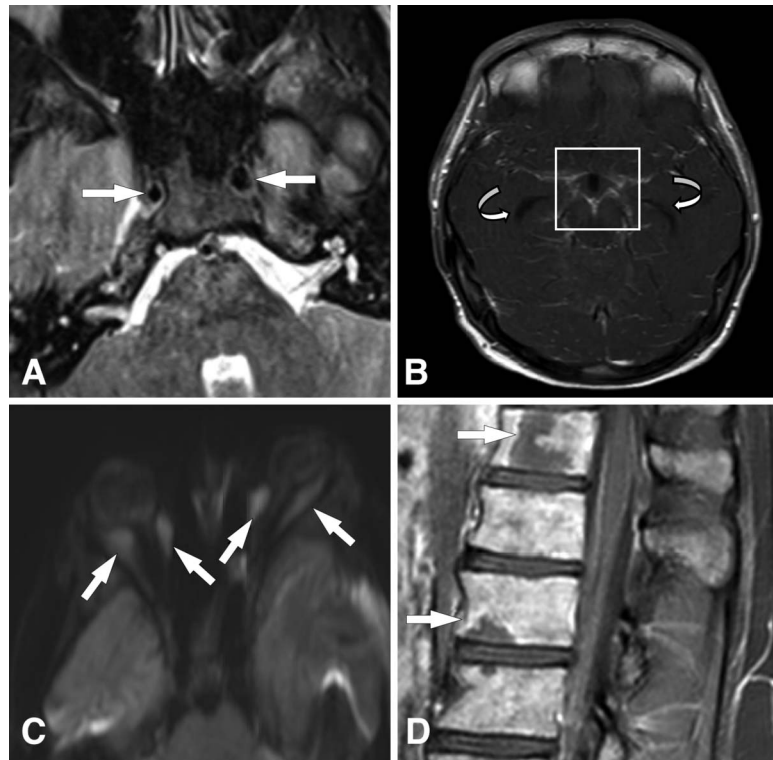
Axial T2-weighted image (A) from the initial MRI show mild vasospasm of the right internal carotid artery. Notice the caliber difference between the right and left ICA (*arrows*). Postcontrast T1-weighted image (B) follow-up MRI study shows diffuse postcontrast enhancement of the basal cisterns (box) with mild interval development of the ventricles (*curved arrows*). Diffusion-weighted image (C) from the follow-up MRI shows bilateral postseptal soft-tissue tumor infiltration of the extraocular muscles (*arrows*). The sagittal postcontrast T1-weighted image of the spine (D) shows diffuse marrow space heterogeneous enhancement (*arrows*), suggesting tumor infiltration.
